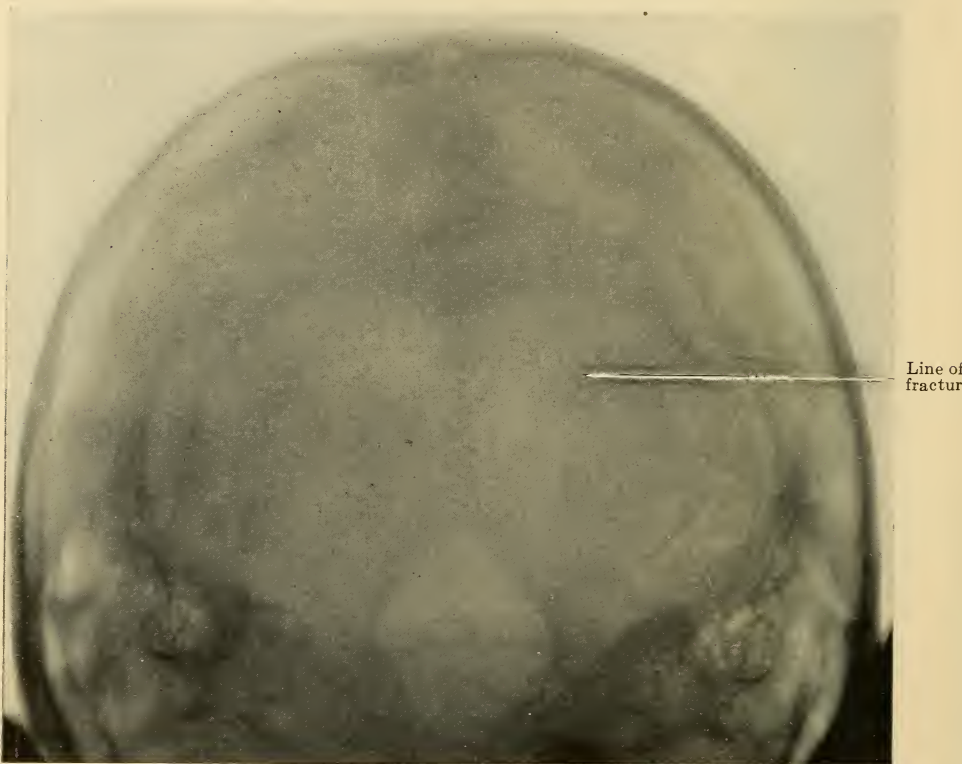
Esther R. This patient of twenty-four years of age fell while skating upon the ice, striking the back of her head. No immediate loss of consciousness; was able to walk home and to eat at the dinner table in spite of a "dull headache." Vomiting occurred two hours later, and at three o'clock (six hours after the injury), it was found that she could not be aroused to consciousness; her pulse was then fifty-four and respirations twelve and of a Cheyne-Stokes character. Upon admission to the hospital one hour later, an X-ray picture revealed a narrow linear fracture extending vertically downward and backward from the right parietal bone through the right half of the occipital bone into the right margin of the foramen magnum. The condition of the patient quickly changed after admission to the hospital in that the signs of medullary compression merged into those of an acute medullary edema—a rapidly ascending pulse- and respiration-rate, so that the patient was *in extremis* before the preparations for the operation of suboccipital decompression could be made. The autopsy revealed a large subtentorial hemorrhage directly compressing the medulla. An earlier operation would have afforded this patient a definite chance of recovery; the delay necessitated by an X-ray picture was inexcusable.
